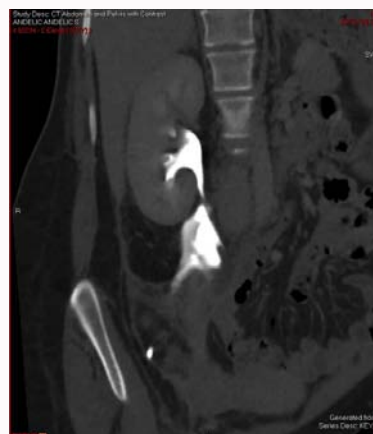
Coronal reconstruction of CT urogram showing extravasation of contrast from the proximal right ureter.
